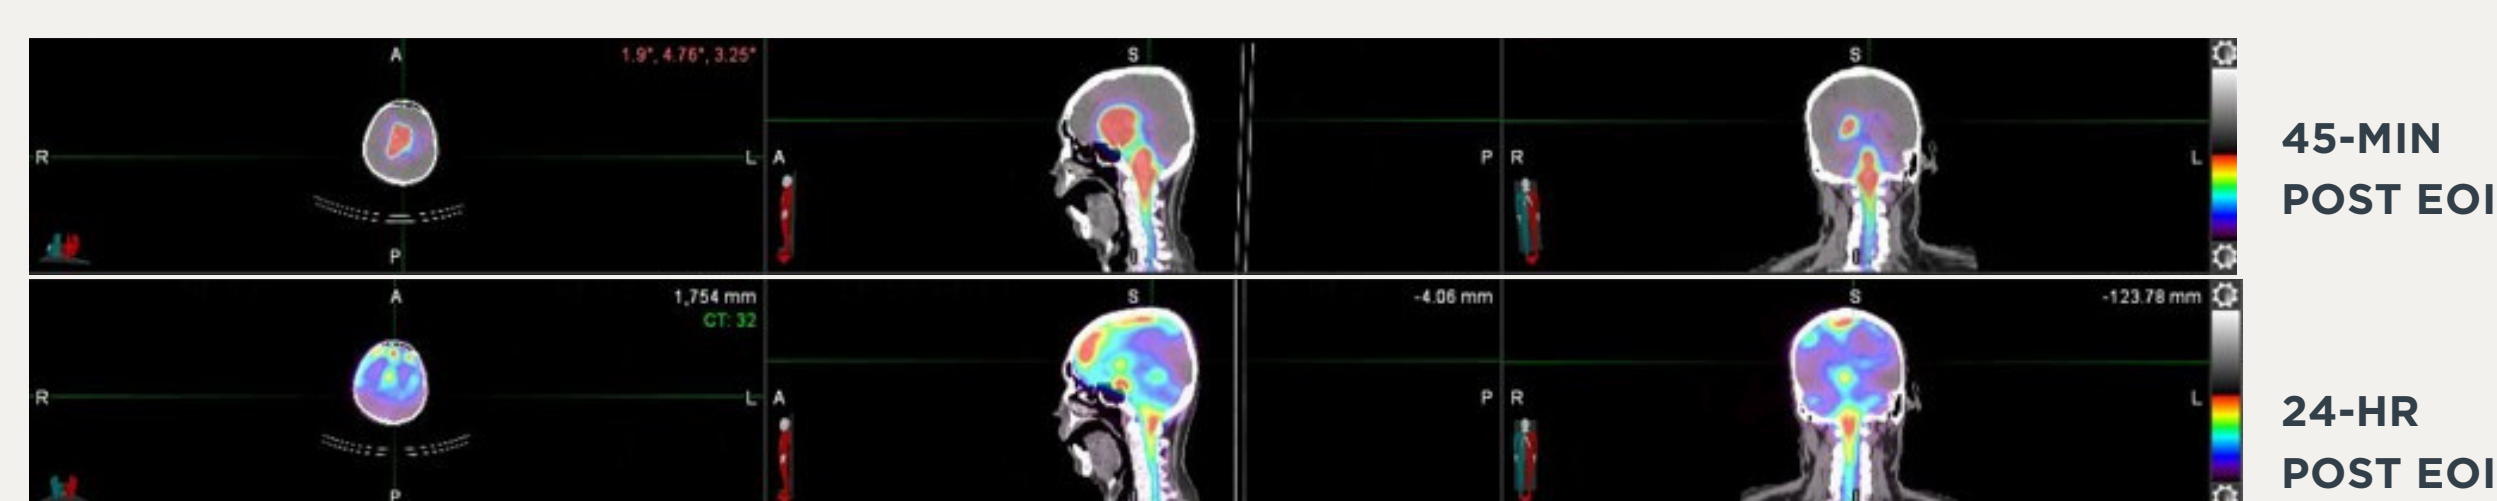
SPECT/CT of LM patient in cohort 2 (13.2 mCi injected activity) at 45-min and 24-hours post intraventricular ¹⁸⁶RNL infusion through the Ommaya reservoir.
